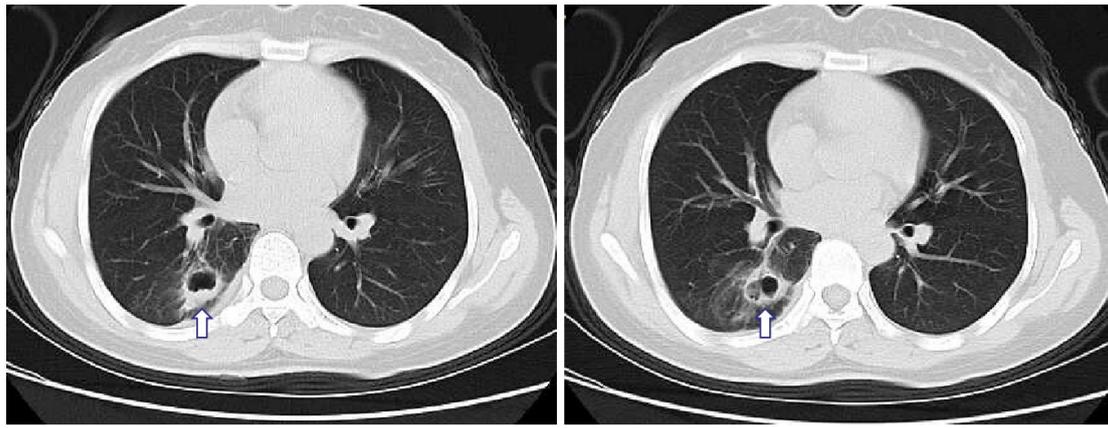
Chest CT scan was performed on 27 November 2012. The area indicated by the arrow was the thick-walled cavity-like lesion of the right lower lobe.
